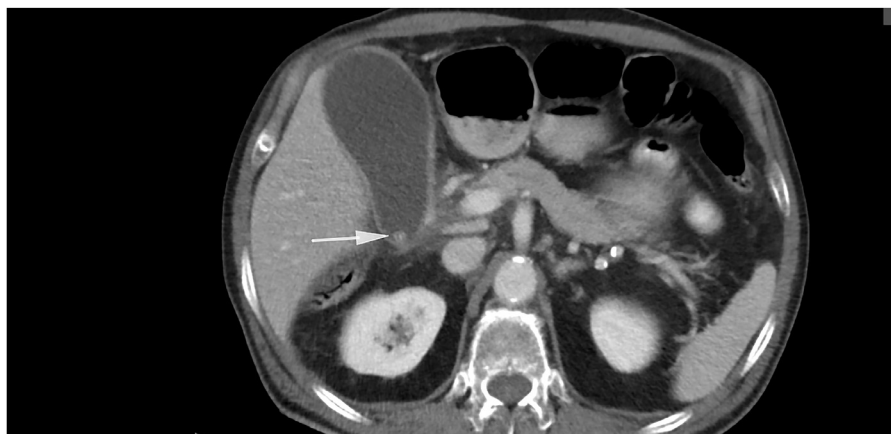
Prior contrast-enhanced computed tomography of the patient, several months before laparoscopic cholecystectomy, shows the same stone (arrow) in the gallbladder.
